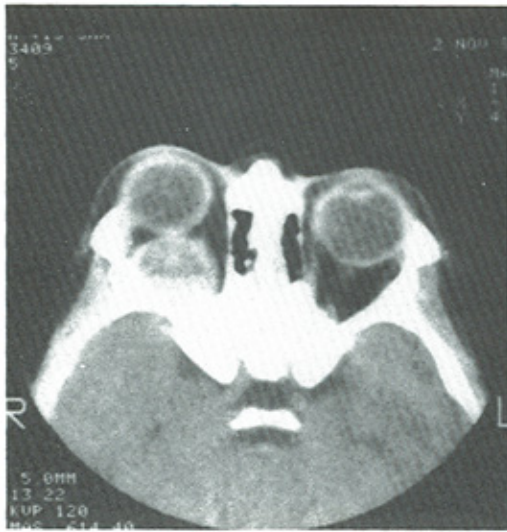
Computed tomographic scan demonstrating the orbital tumor with a contrast-enhancing periphery. Coronal views revealed the presence of intracranial extension (arrow). (Courtesy of Dr. A. Weber.)
